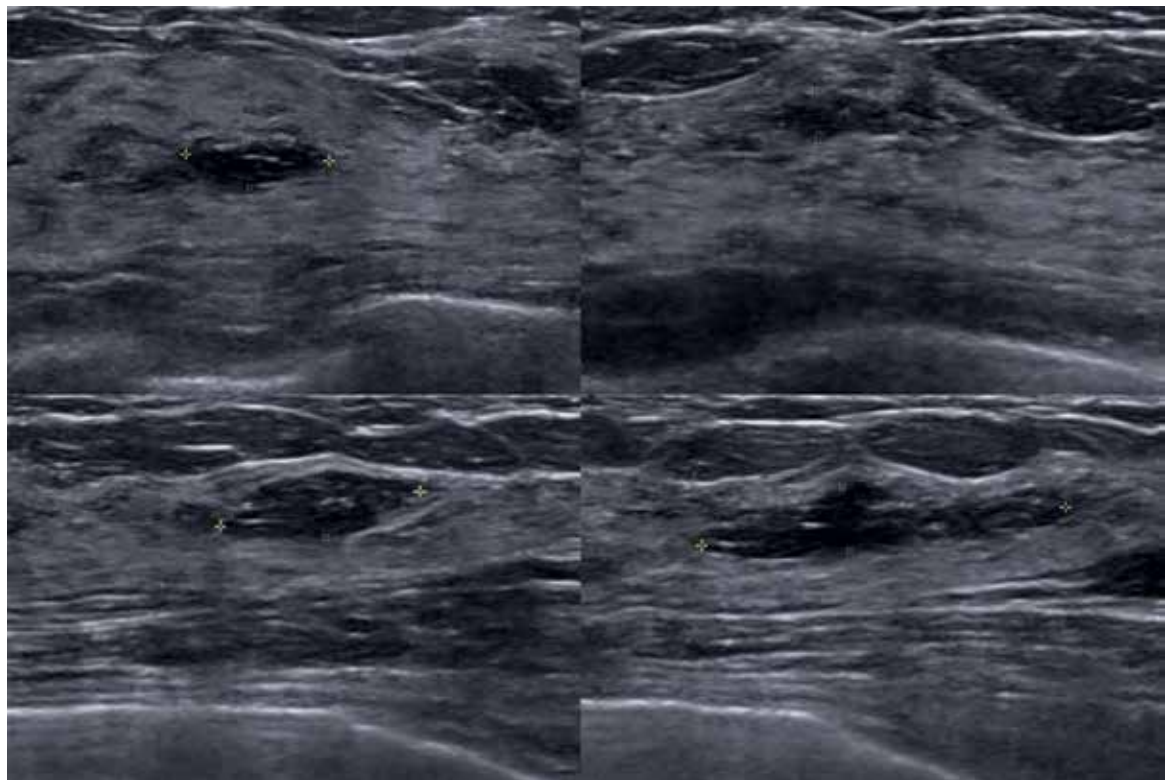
Breast ultrasonogram showing multiple benign-looking lobulated and oval circumscribed hypoechoic masses measuring up to 2 cm at the upper inner and upper outer quadrants of the right breast
